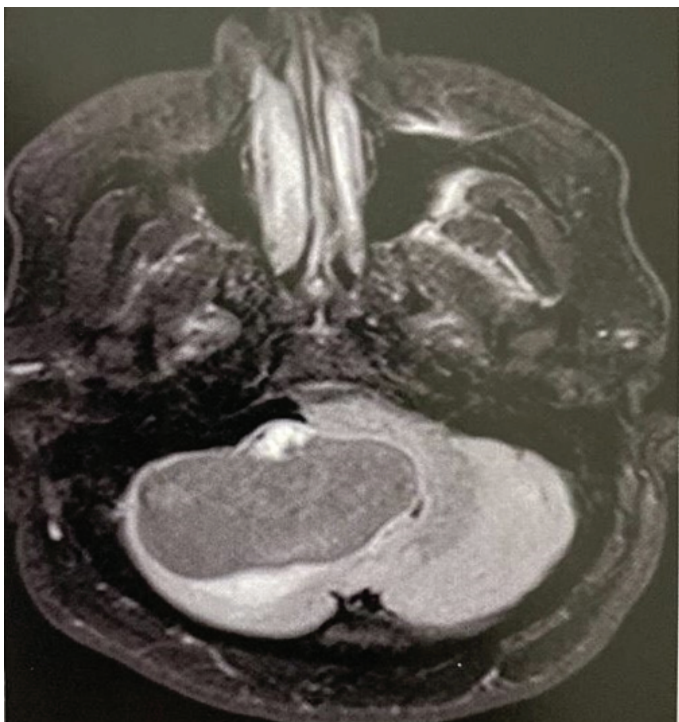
T1-weighted cranial MRI, axial section, showing a cystic lesion in the cerebellar region with an intramural nodule.
